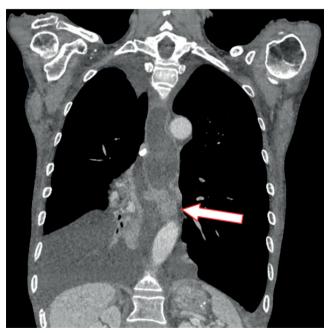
Hydro-computed tomography (CT) image of the esophagus in coronal reconstruction shows an irregular, circumferential wall thickening up to 11 mm in depth in the proximal and middle third of the esophagus, with inhomogeneous enhancement and blurred outer borders in terms of the T3 tumor
